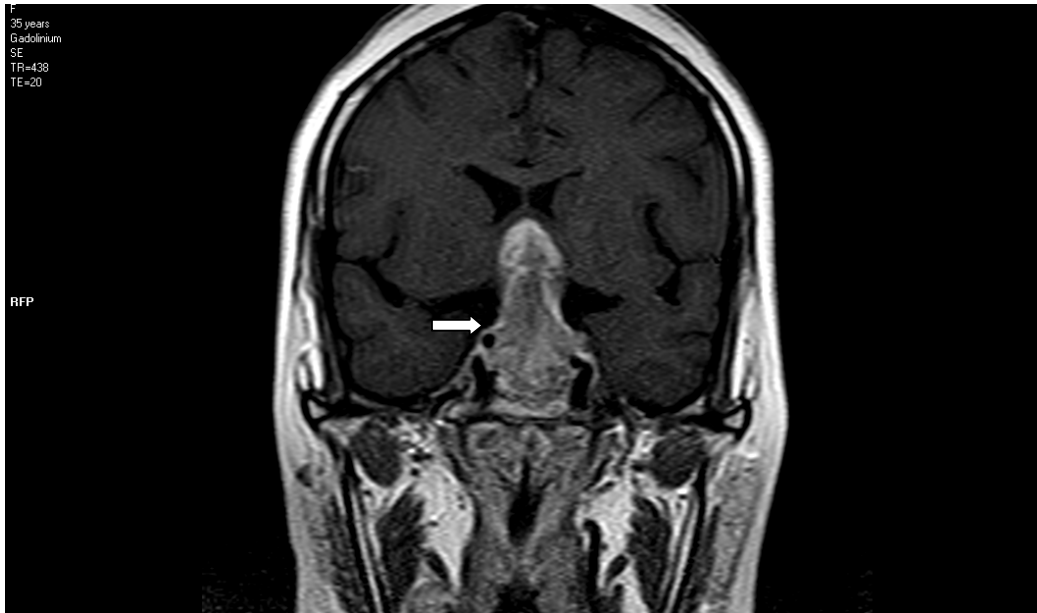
MRI Brain Coronal T1W with contrast showing macroadenoma for 35 years old female
